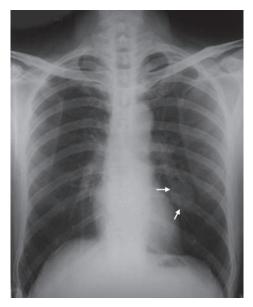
Chest X-ray shows solitary pulmonary nodule or coin lesion (arrows) in left lung field in paracardiac location
